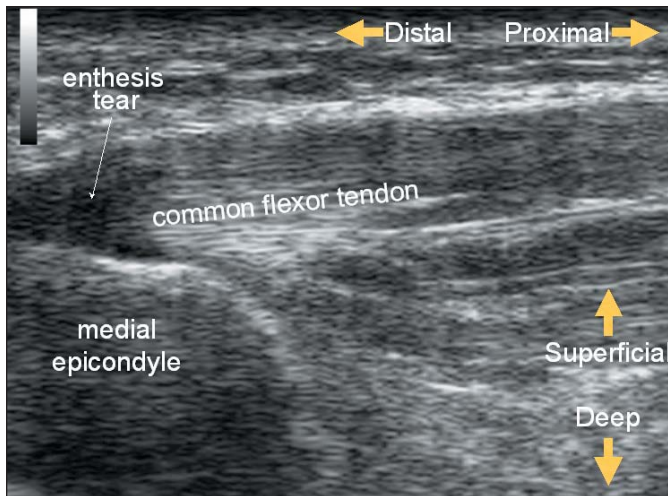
Ultrasound image of medial epicondylitis in 33-year-old patient of two years continuous duration (origins in high school tennis).*
